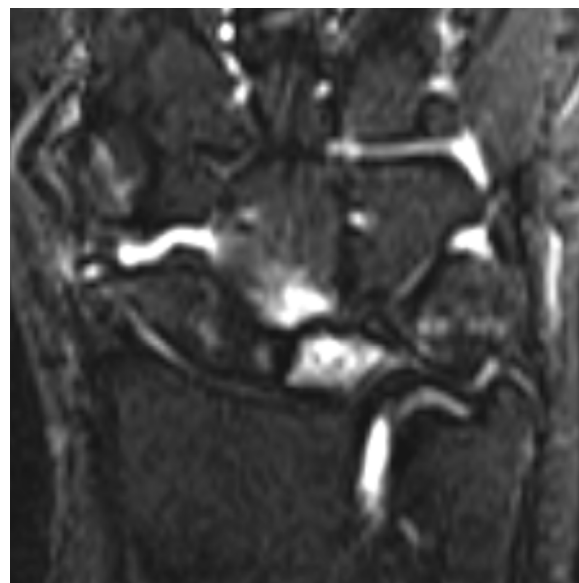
Postoperative magnetic resonance imaging of the right wrist in patient 3, a 67-year-old woman with stage IIIb Kienböck's disease.
